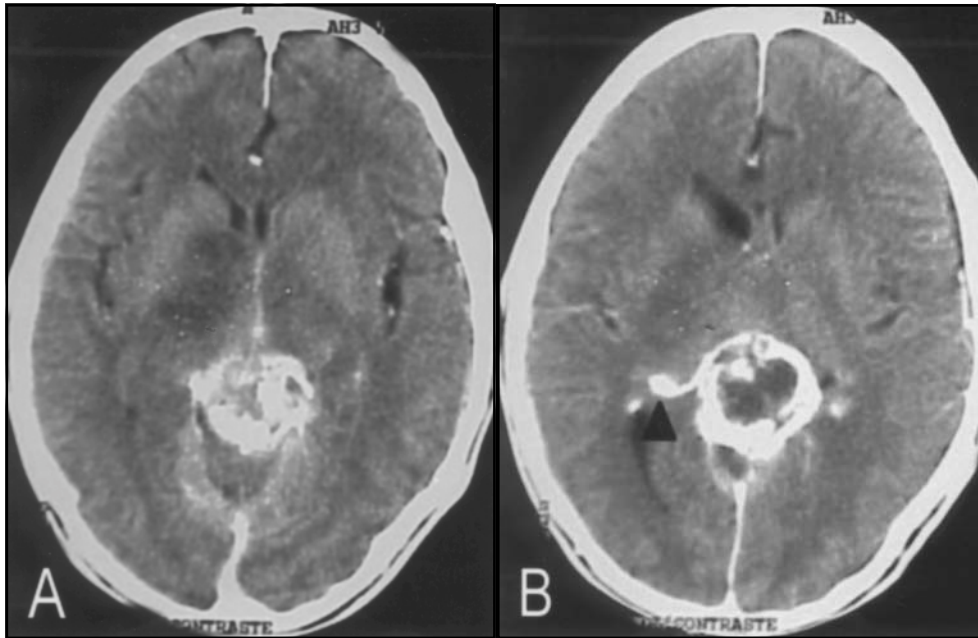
(A) and (B). Axial CT scan after contrast injection revealing heterogeneous enhancement of the mass and demonstrating the invasion of the right thalamus (arrow).
